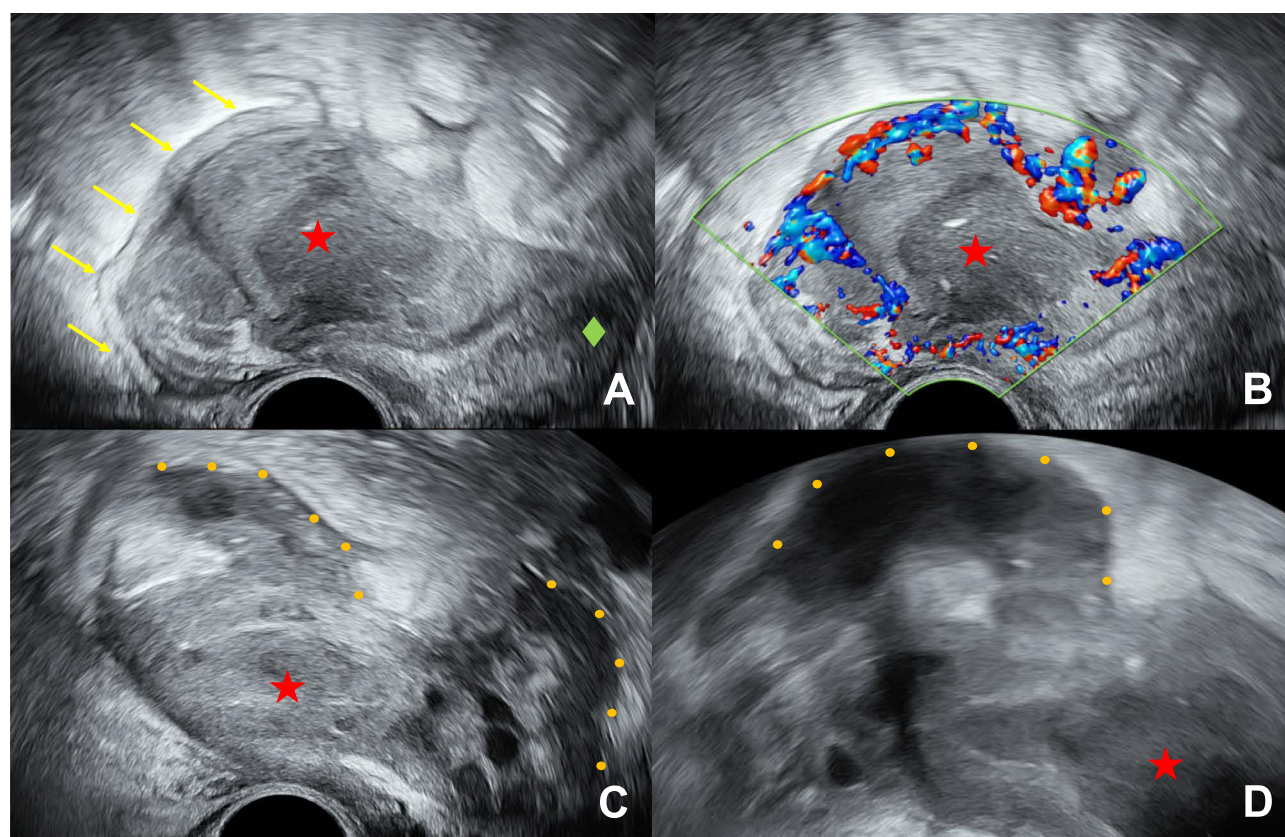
Transrectal ultrasound. (A) Inhomogeneous mass (red star) in the pouch of Douglas. The mass is ventrally confined by and tightly adherent to the posterior uterine wall (green diamond). Dorsally, the mass has direct and extensive contact to the rectosigmoid (yellow arrows). (B) On color Doppler imaging no blood flow can be detected in the center of the inhomogeneous mass (red star), underlining its cystic nature. However, in the periphery there is very strong perfusion. (C) Hypoechoic tubular structures (Orange dots) to the left and right connect to the inhomogeneous mass (red star) in the middle. (D) Closer image of the prominent hypoechoic tubular structure on the right (orange dots), connecting to the inhomogeneous mass (red star).
